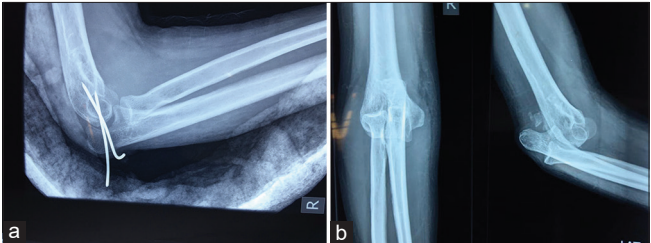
Reduced dislocation of the elbow joint with cross Kirschner's wire fixation (a) Post operative X-ray showing reduced elbow joint with cross K-wires insitu, (b) Pre-operative X-ray showing neglected dislocation of the elbow joint
